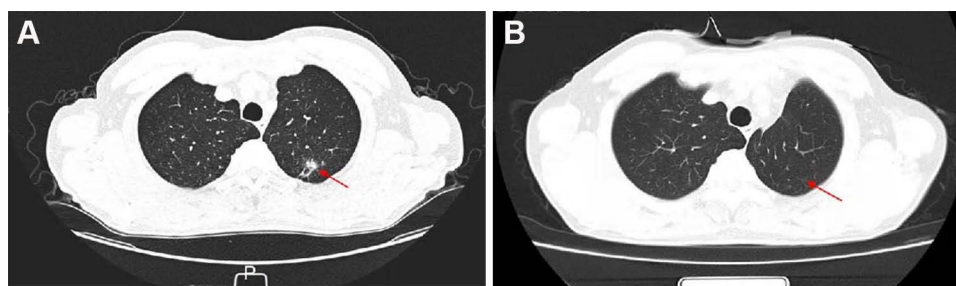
Chest computed tomography revealed the different stages of the patient's lung tumor. (A) Initial diagnosis revealed a nodular high-density shadow in the posterior segment of the upper lobe tip of the left lung in April 2020. (B) CT scan after the surgery in June 2020.
